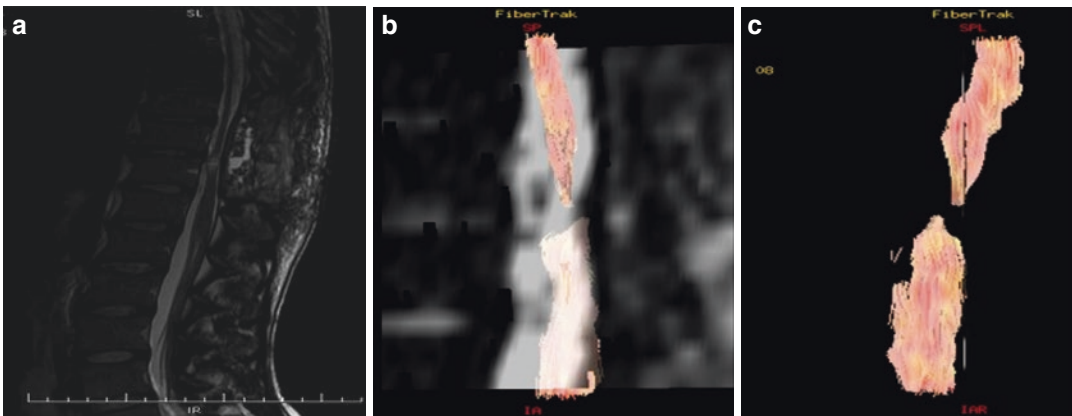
(a) Sagittal T2-weighted image demonstrates SCI lesion at T12. (b, c). DTI tractography images demonstrate disruption of the white matter fibers at the same level. (Reprinted with permission from Sasiadek et al. [202])
